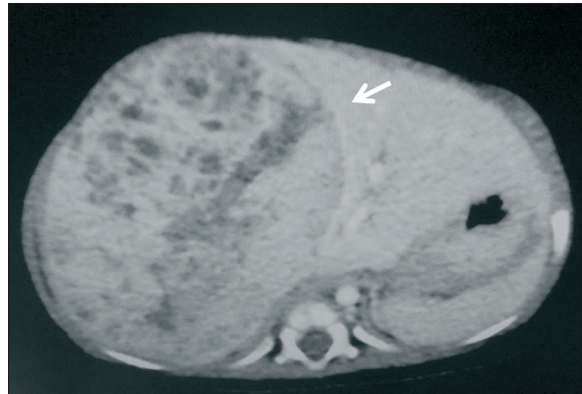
Prechemotherapeutic CT. A middle hepatic vein is performed exclusion of along mass margins (arrow).
